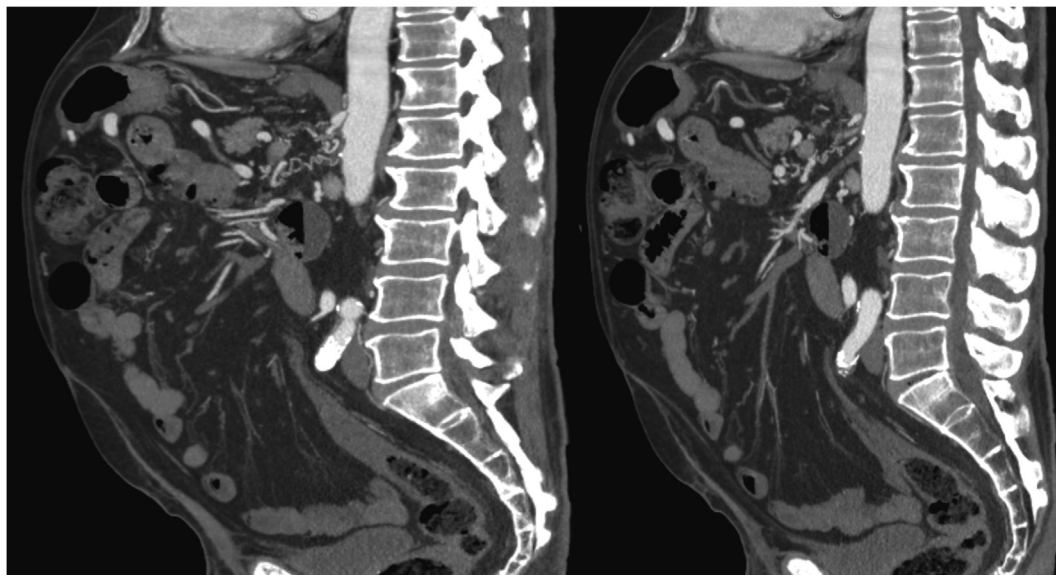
Computed tomography angiogram demonstrating the occluded celiac artery and associated corkscrew collaterals (A) and superior mesenteric artery (SMA; B).
